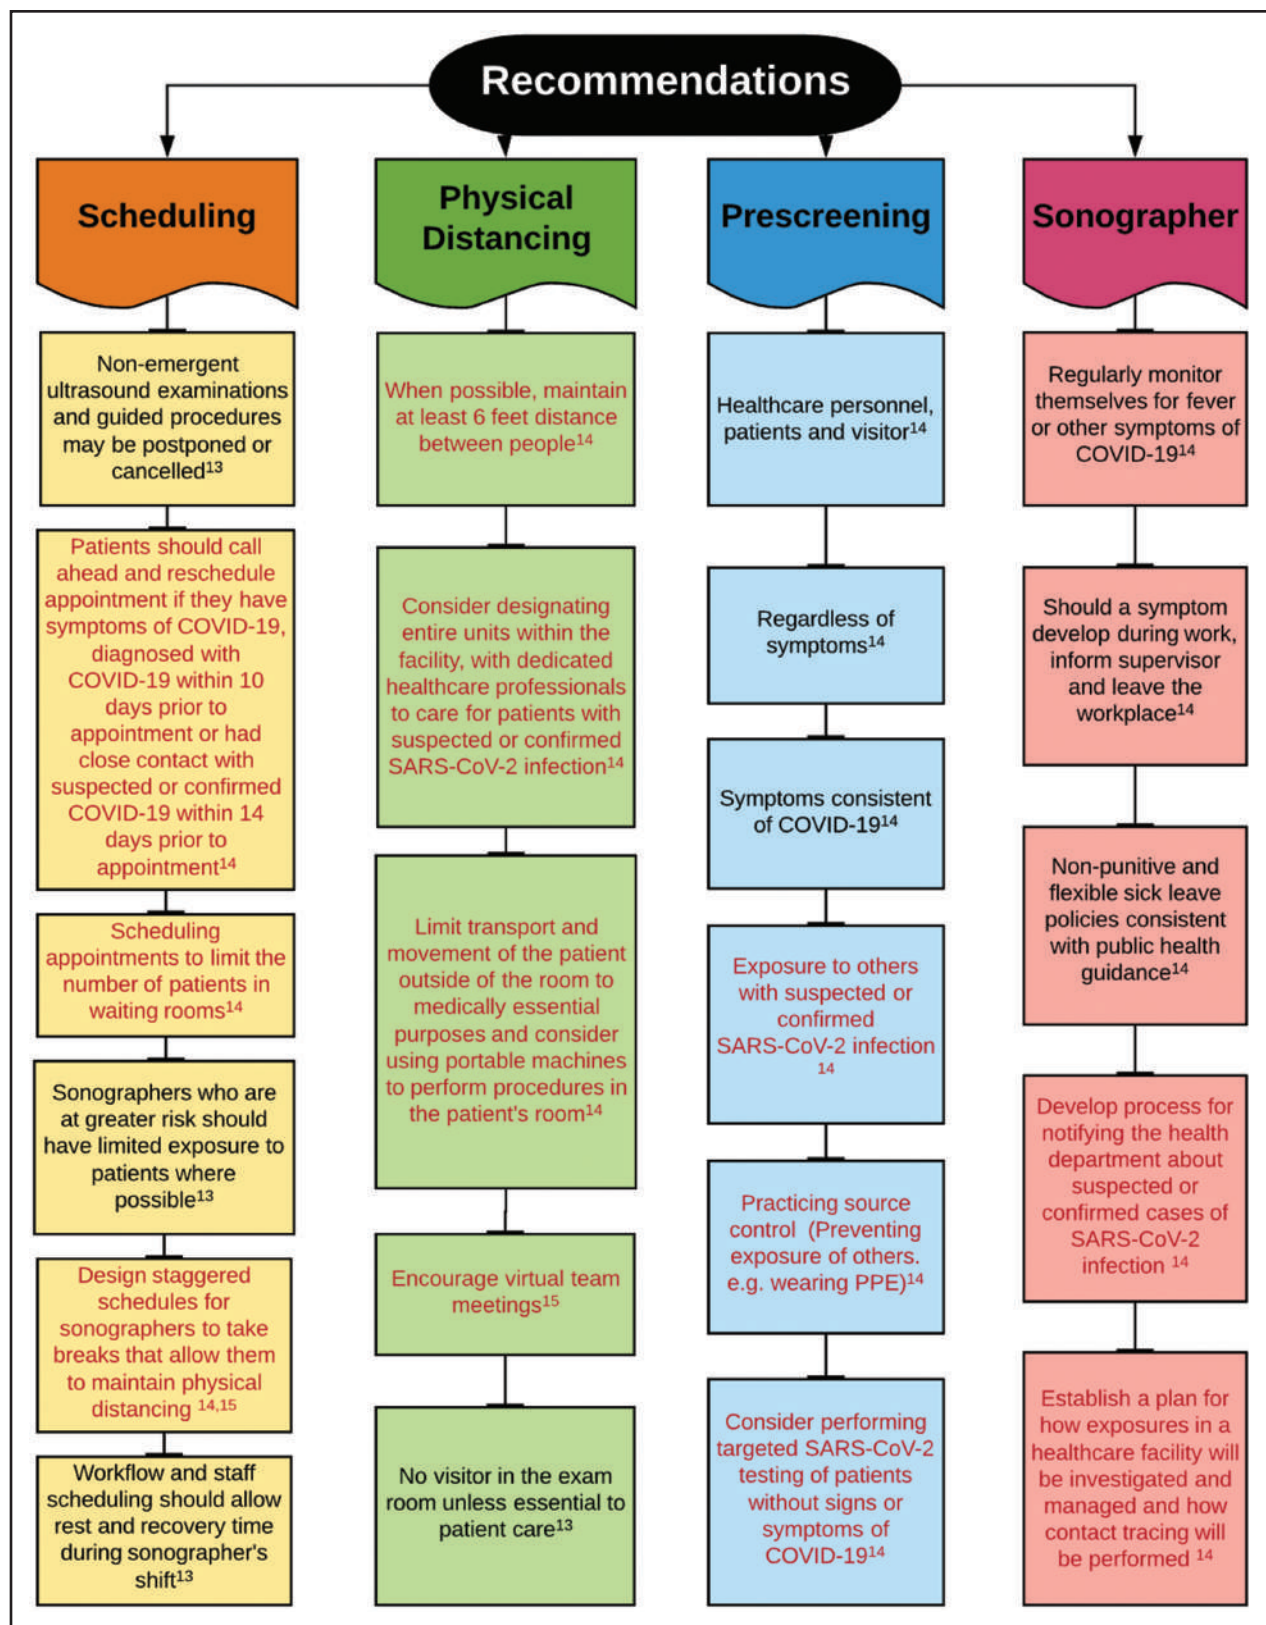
Recommendations for sonographers and healthcare facilities.
